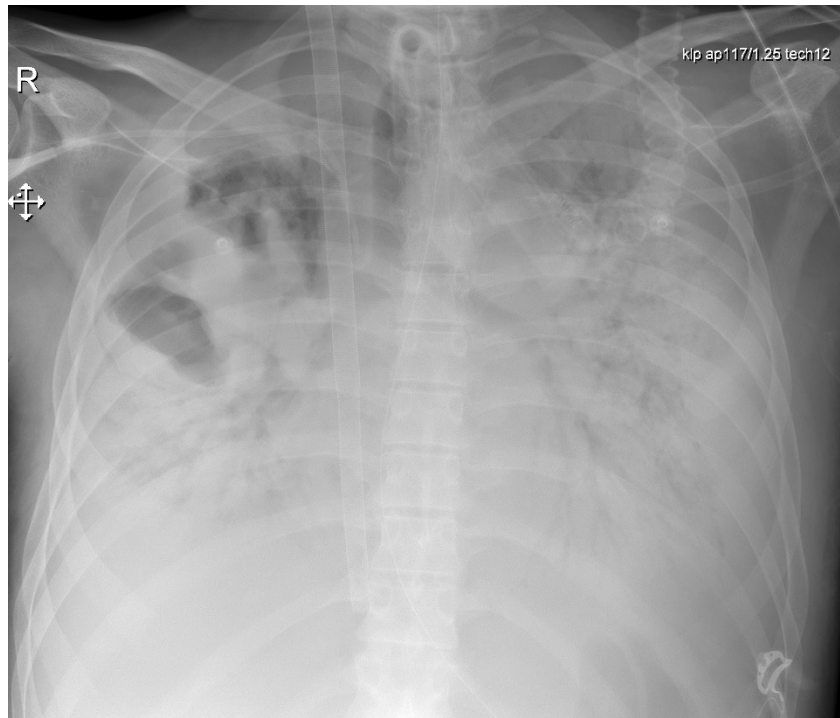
Chest X-ray revealing extensive infiltrates in the pulmonary tissue, areas of pneumothorax – due to which the patient had a drain to the right pleural cavity – and bicaval dual lumen cannula for ECMO.
